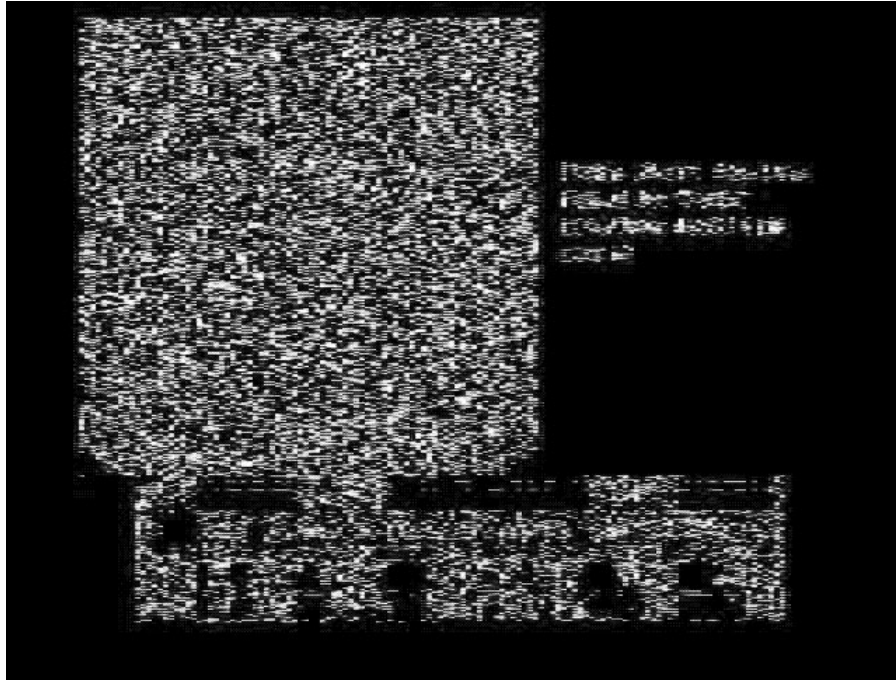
depicts a set of results tested on the acute intracranial hemorrhage CAD. Fig. 8(a) shows of the original CT image with its digital signature embedded and Fig. 8(b) the subtracted image between the signature embedded CT image and the original CT image. Fig. 9(a) shows the DICOM SC annotated image with its signature embedded and Fig. 9(b) the subtracted images between the signature embedded DICOM SC image and the original DICOM SC image. Fig. 10(a) shows the DICOM SR of the acute intracranial hemorrhage CAD textual result with the digital signature appended to the DICOM SR file and Fig. 10(b) the information of the digital signature. The digital signature was appended to the end of the DICOM SR file based on the DICOM SR RSA Digital Signature Profile.
